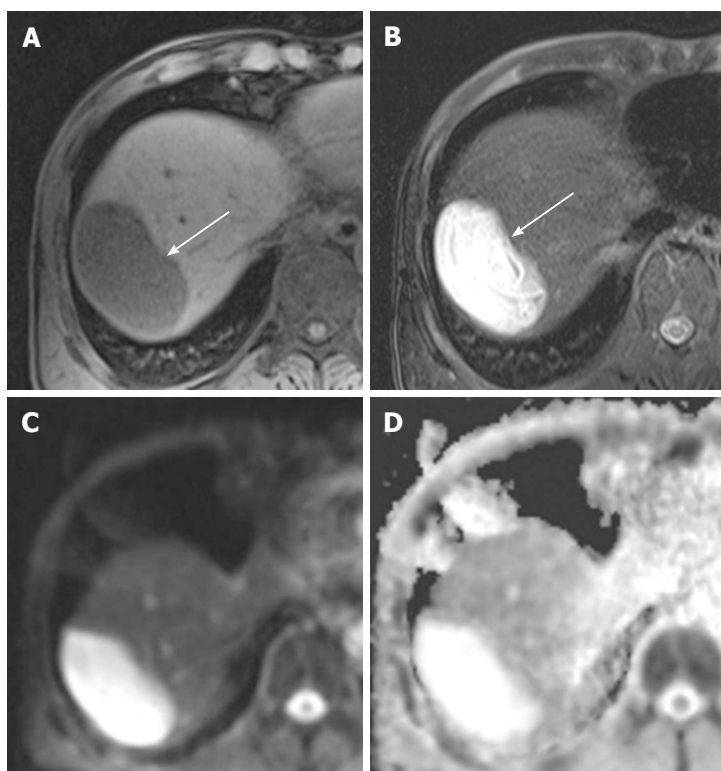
Liver magnetic resonance imaging. A: Axial nonenhanced T1-weighted image showing that this hepatic mass (arrow) exhibits homogeneously low signal intensity; B: Fat-saturated axial T2-weighted image showing that the mass (arrow) exhibits very high signal intensity and internal serpiginous tubular structures; C and D: Axial diffusion-weighted image (C) and apparent diffusion coefficient map (D) showing that the diffusion in the mass is not restricted.
